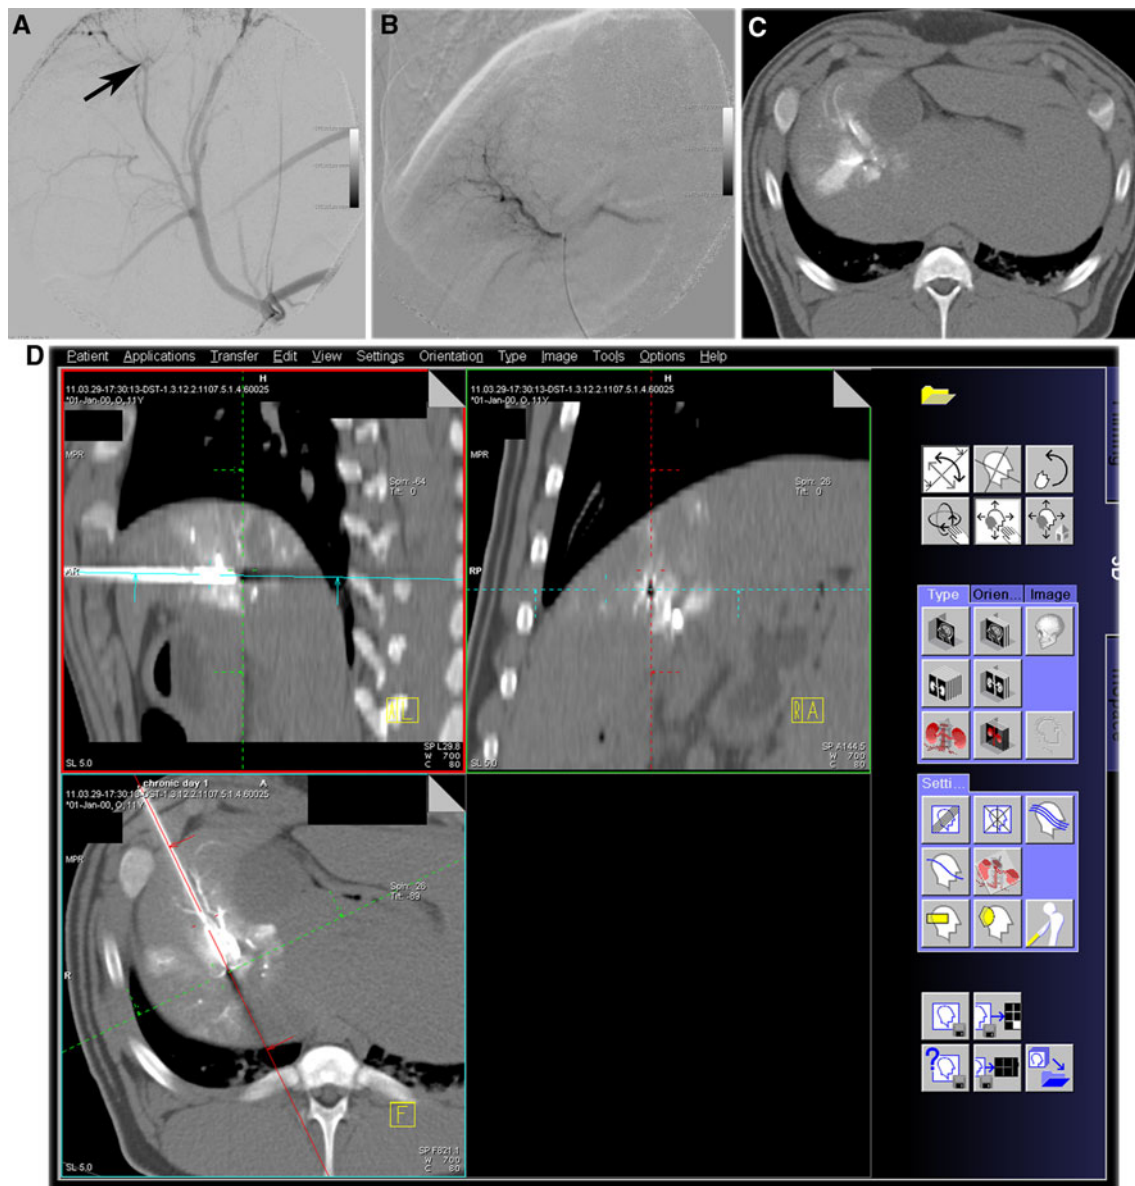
A Celiac arteriography via a 5F catheter. A microcatheter was inserted into a branch of the right hepatic artery, which was supplying into the anterior–superior segment of the right part of the liver (arrow). B Superselective arteriography via the microcatheter. C CT
